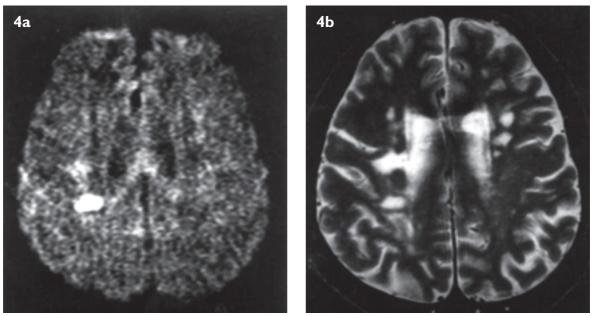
(a) DW scan at 24-48 hours post-ictus unambiguously identifies the acute infarct (graded 4) in the posterior right corona radiata. (b) T2-weighted scan demonstrates multiple subcortical lacunar infarcts (scored 3), but distinguishing the acute lesion is impossible even with clinical input.
